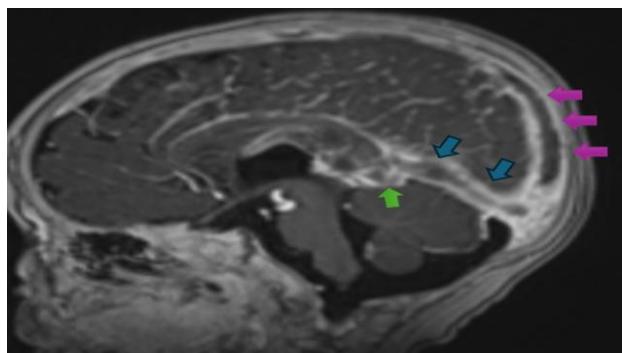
Sagittal T1-weighted brain MRI after gadolinium injection showing a lack of opacification of the superior sagittal sinus, straight sinus, and vein of Galen, with visualization of intraluminal thrombi. Pink arrow: thrombus within the superior sagittal sinus; blue arrow: thrombus within the straight sinus; green arrow: thrombus within the vein of Galen.
